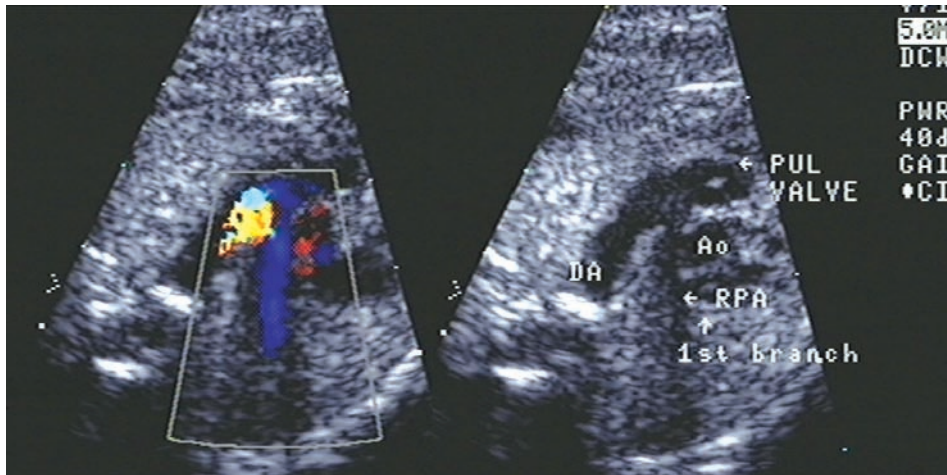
Site of pulmonary Doppler imaging.
